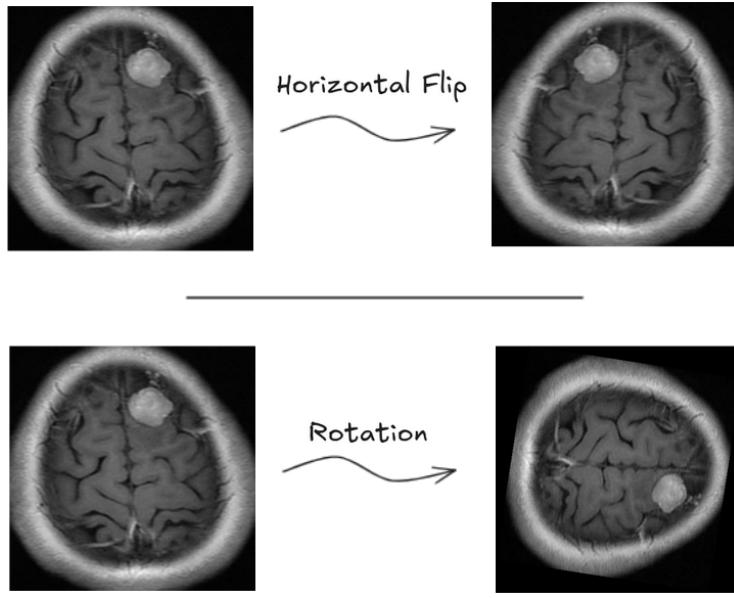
Examples of data augmentation applied to brain MRI images. Top: horizontal flipping. Bottom: random rotation. These transformations preserve anatomical structure while increasing training data variability.
